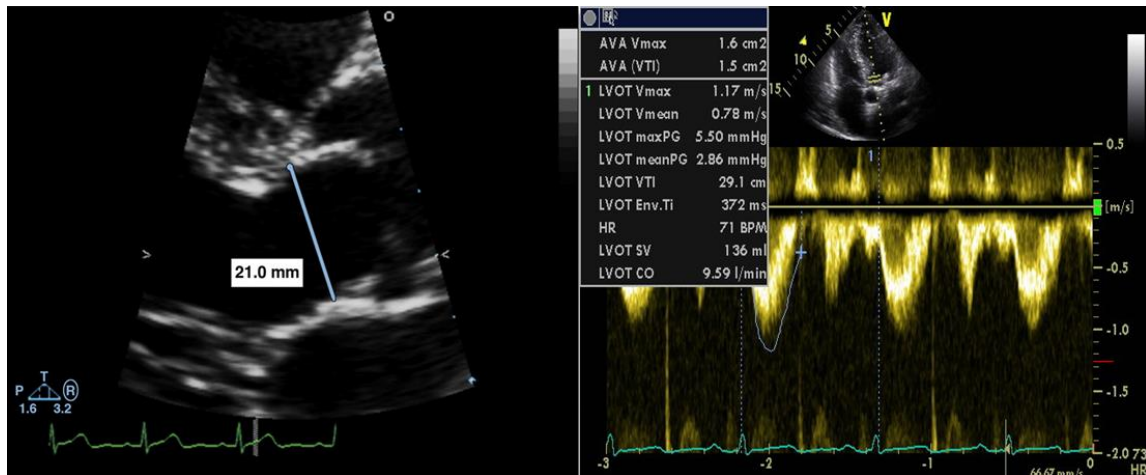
Determination of stroke volume by echocardiography.
